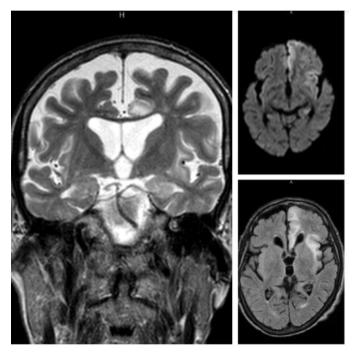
FLIAR T2* T2 Brain MRI showing significant progression with left frontal, mesial temporal, insular cortical and subcortical signal changes.
